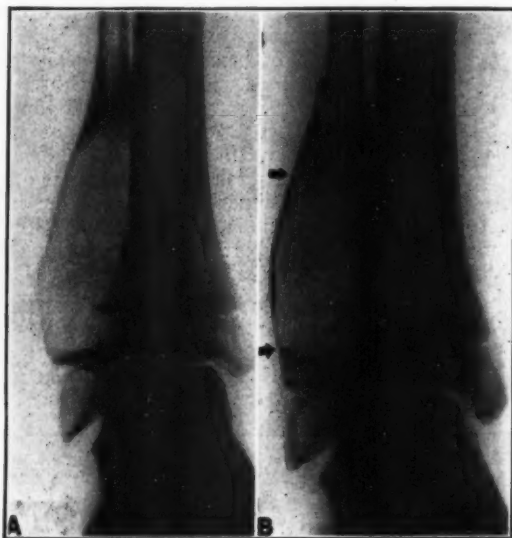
A. (Case 4). Giant cell tumor lower end of fibula. (B) After X-ray treatments note the borders of the involved area show definite filling in with new bone. The case is still under treatment and complete healing may be expected after several months, in spite of the slow response to treatment.
